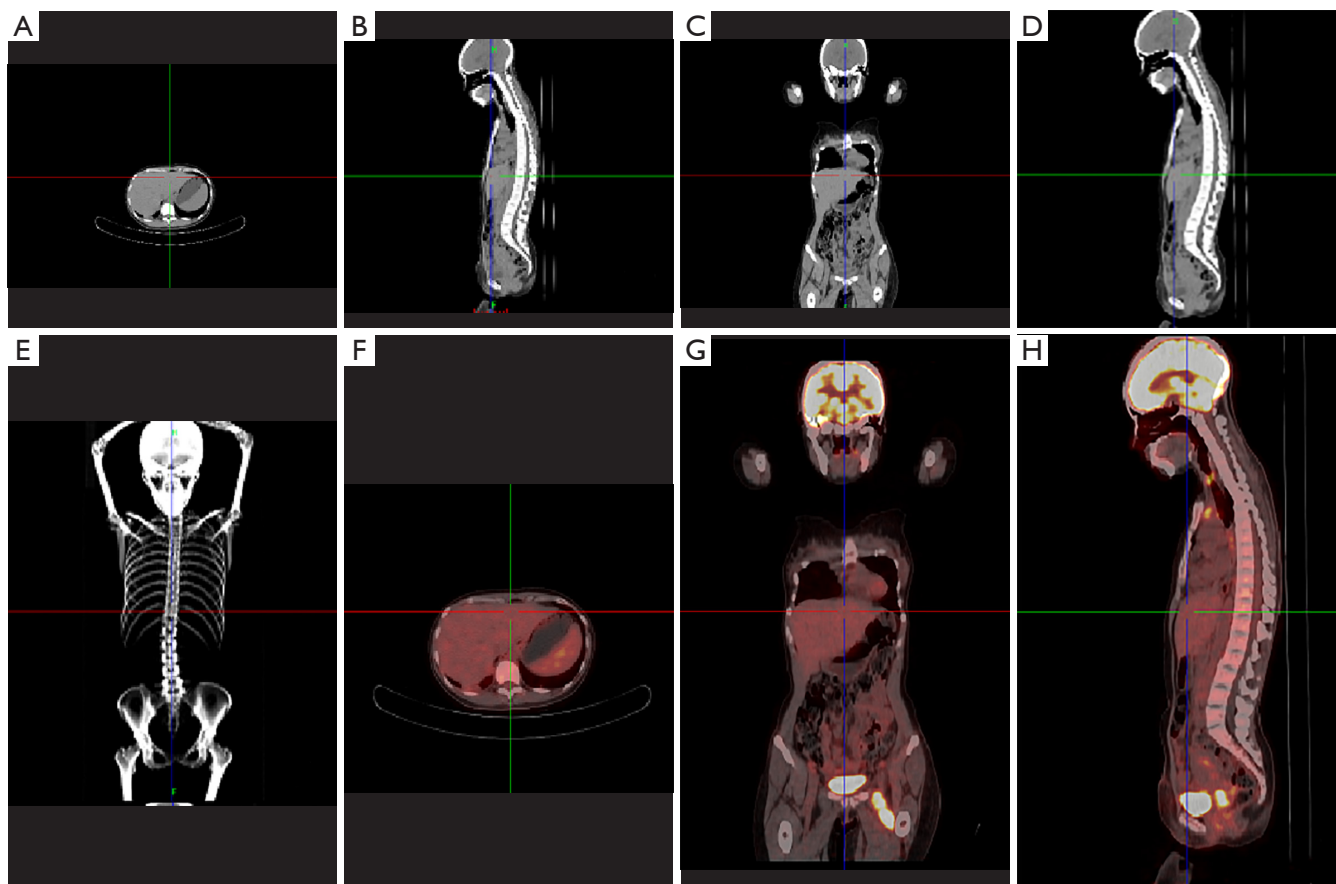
18F-FDG PETCT imaging of a typical case. 18F-FDG PETCT, 18F-fluorodeoxyglucose imaging examination. (A,B,C,D,E) 18F-FDG PETCT imaging showed that the cervical volume of patient was increased, the local soft tissue was thickened and glycometabolism was increased, which was considered as cervical Ca. (F,G) Multiple lymph nodes in the left carotid chain region (II, III, IV), the left posterior cervical triangle, the supraclavicular, mediastinal, retroperitoneal, left axillary, bilateral inguinal, pelvic, and para-aortic regions showed partial enlargement, fusion, and high glycometabolism, which was considered of the possibility of lymph node metastasis. (H) Local swelling of the left pubis, left iliopsoas, left gluteus medius, and high glucose metabolism, considering as metastasis.
